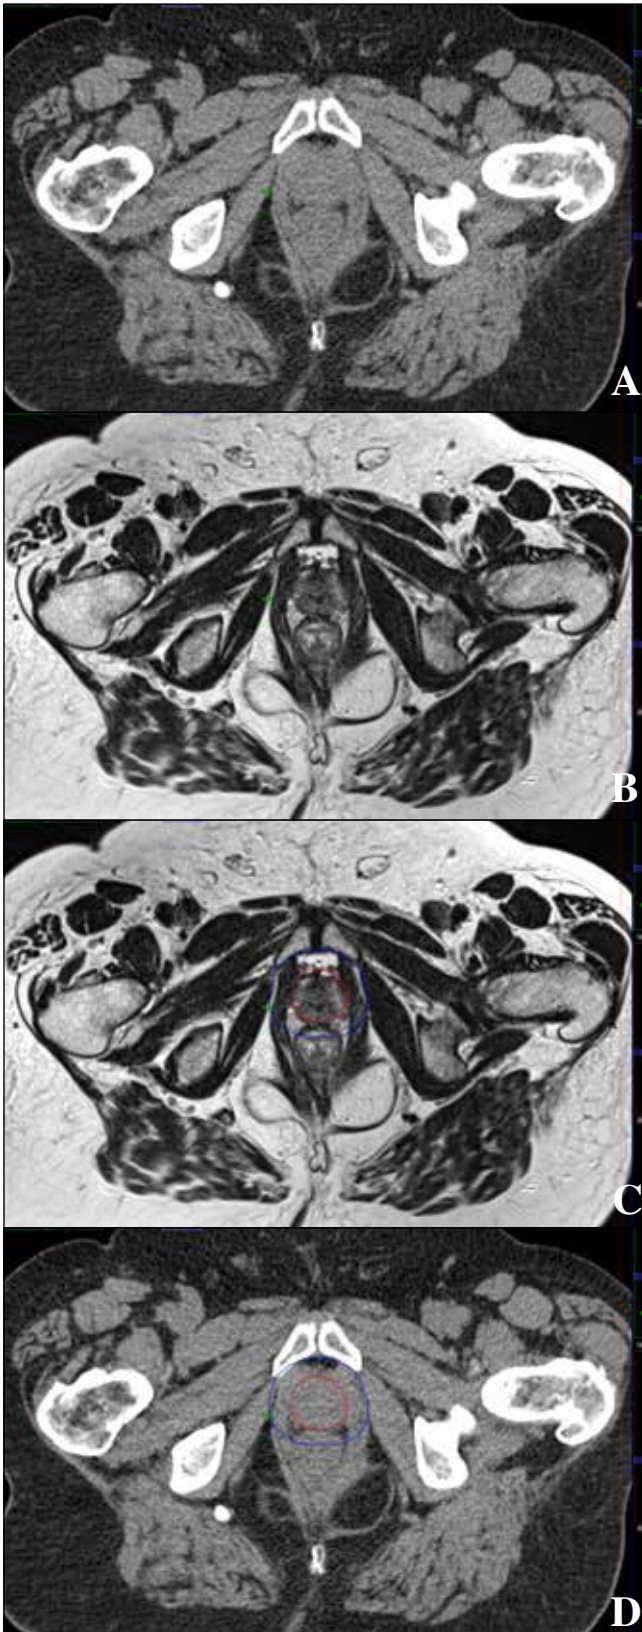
poorly visualised pelvic anatomy on CT scans (A) such as target organs like prostate (red) plus a margin of safety (blue) and organs at risk such as bowel (purple) may be better visualised on MRI images (B) so Oncologists use the latter to define organs (C) and transfer these to the CT images using CT-MRI co-registration (D).
